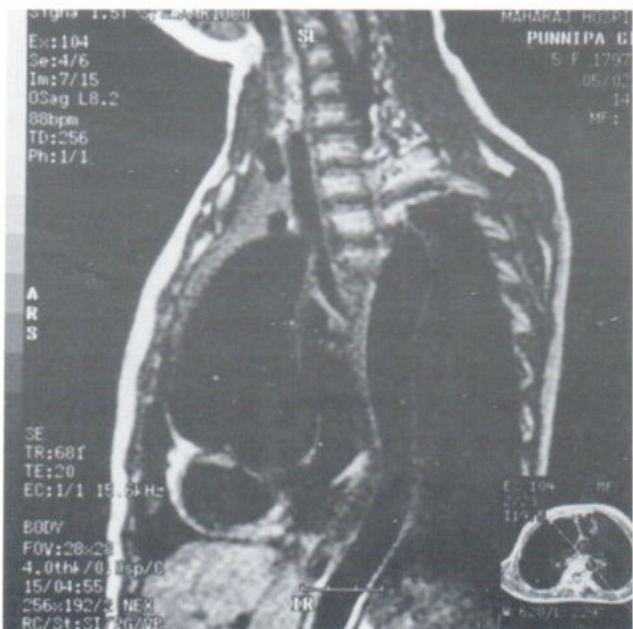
Oblique sagittal MR image shows a huge dilatation of the aortic root and the ascending thoracic aorta.
